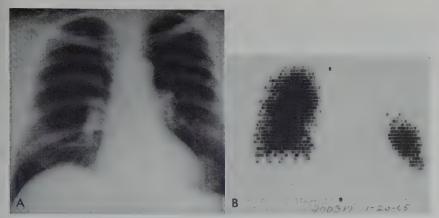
A, Roentgenogram interpreted as showing no abnormality in patient with positive result of cytology and hemoptysis. B, Anteroposterior lung scan demonstrates lack of pulmonary artery blood flow to left upper lobe.
